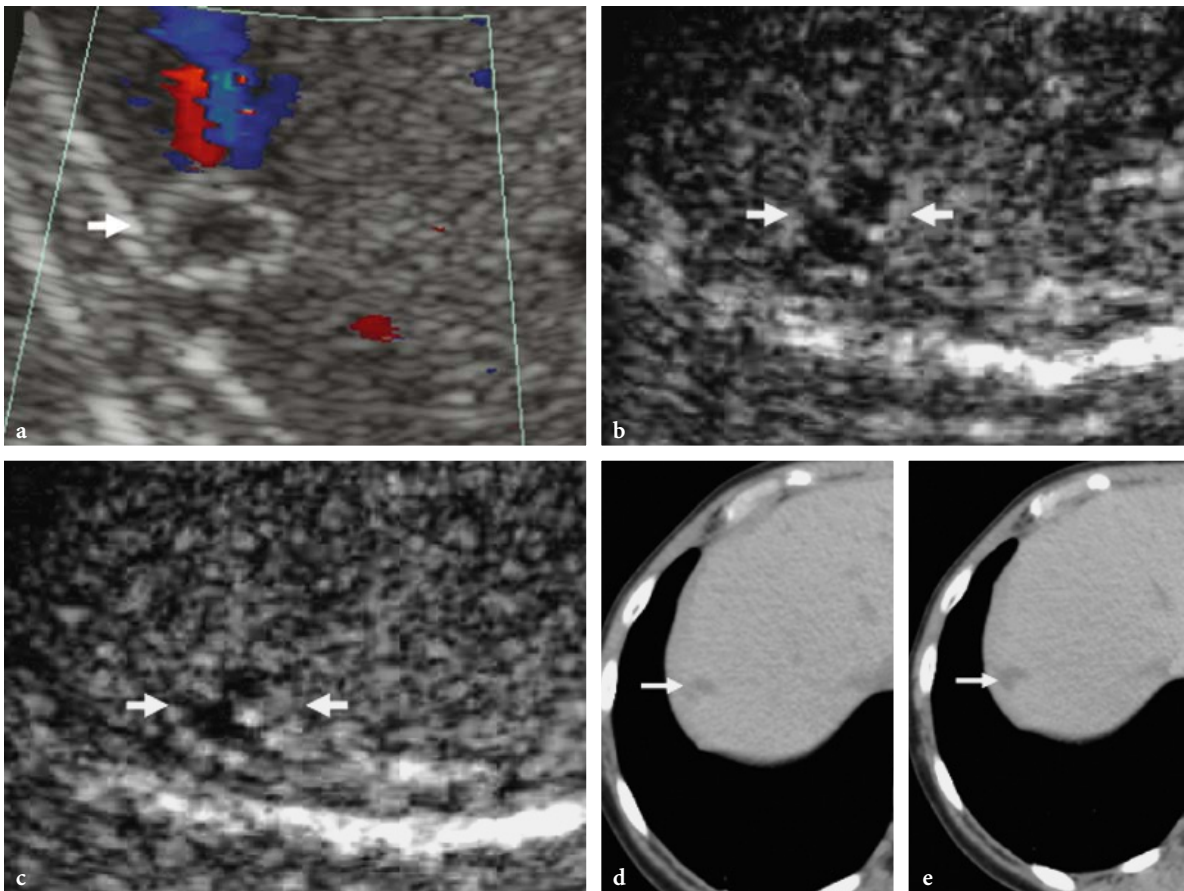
Hemangioma: absence of contrast enhancement in atypical liver hemangioma. a Baseline color Doppler US. A hypoechoic lesion with a peripheral hyperechoic rim and without evidence of peripheral or intralesional vessels is identified. b, c Contrast-enhanced US. Contrast-specific mode: Contrast Tuned Imaging (Esaote, Genoa, Italy) with low acoustic power insonation. There is no contrast enhancement during either the arterial (b) or the late (c) phase, and the lesion has a hypoechoic appearance relative to the surrounding liver. d, e Contrast-enhanced CT. Again, there is no evidence of contrast enhancement after iodinated contrast agent injection, the lesion having a hypodense appearance during both the arterial (d) and the late (e) phase. Hemangioma was proved by US-guided biopsy.
